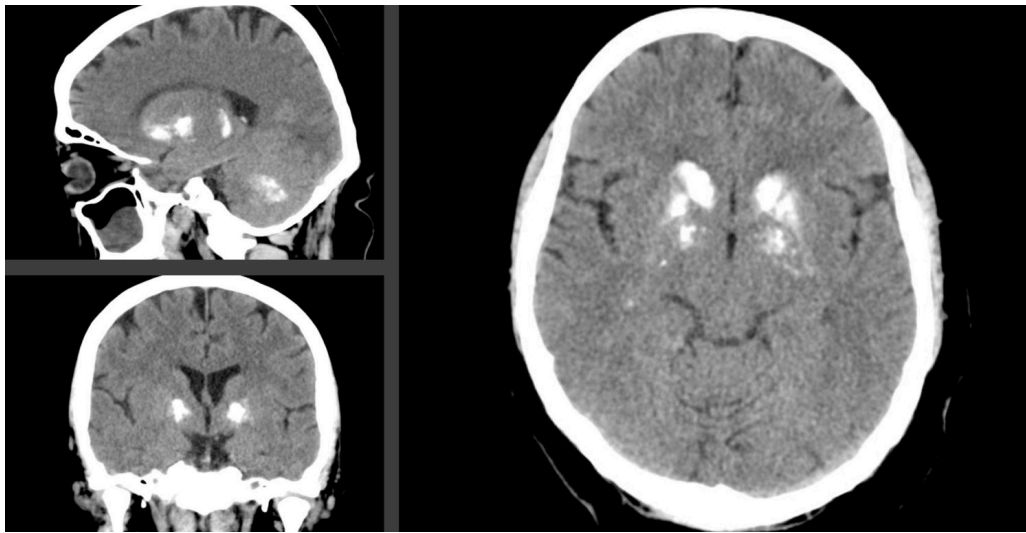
Selected slices from 3D computed tomography (CT) of the head and brain of a person diagnosed with Fahr's disease/primary familial brain calcification. Retrieved from radiopaedia.org (<https://radiopaedia.org/cases/fahr-disease-10>).
